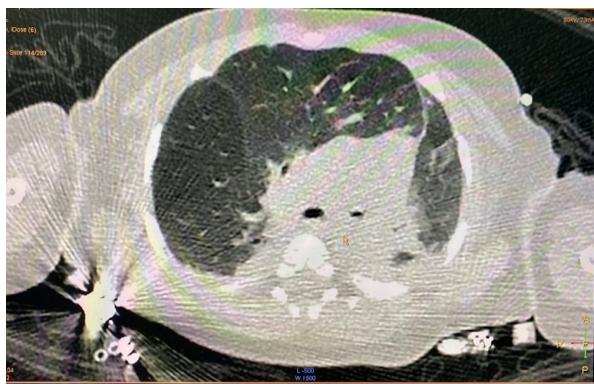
CT scan; fibroatelectasis of the right upper lobe; inflammatory changes in the left lung; narrowing of the left bronchus.
